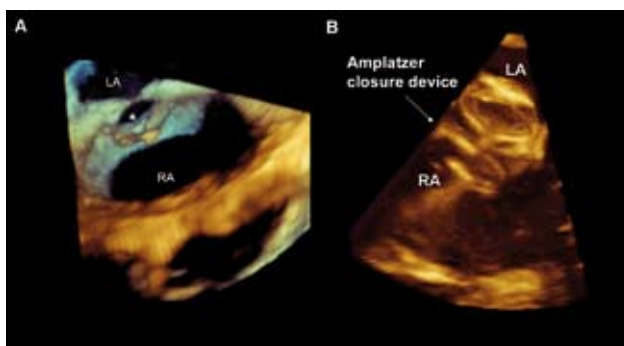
Three-dimensional transesophageal echocardiographic (TEE) imaging during atrial septal defect closure. In panel A, live 3D TEE demonstrates the right and left atria with an atrial septal defect (*). Panel B shows the deployed Amplatzer device closing the septal atrial defect. LA: left atrium; RA: right atrium.
